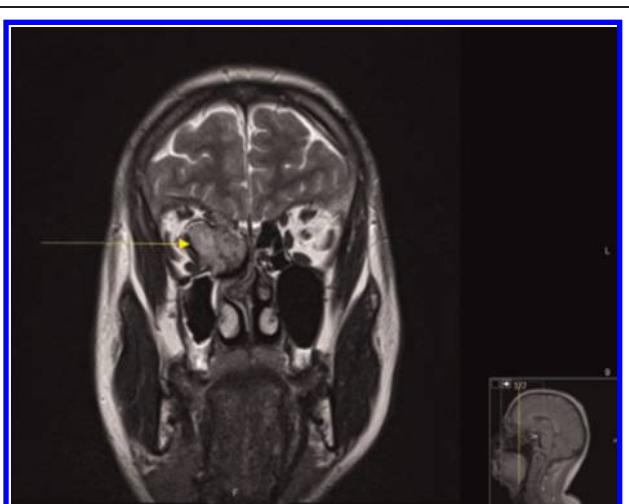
Preoperative coronal magnetic resonance images.
